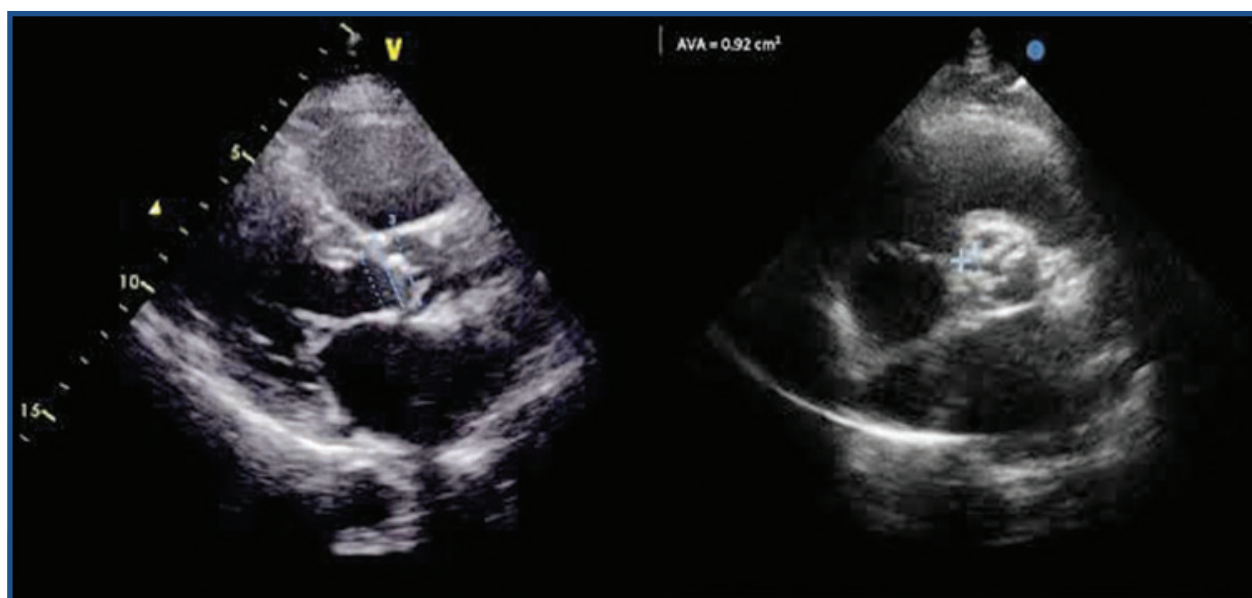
Transthoracic echocardiogram in parasternal long-axis and short-axis view. The aortic valve is examined, with particular attention to the left ventricular outflow tract diameter (1), annulus (2) and sinus of Valsalva width (3). Valvular calcium distribution and planimetric aortic valve area (AVA) are also assessed.
